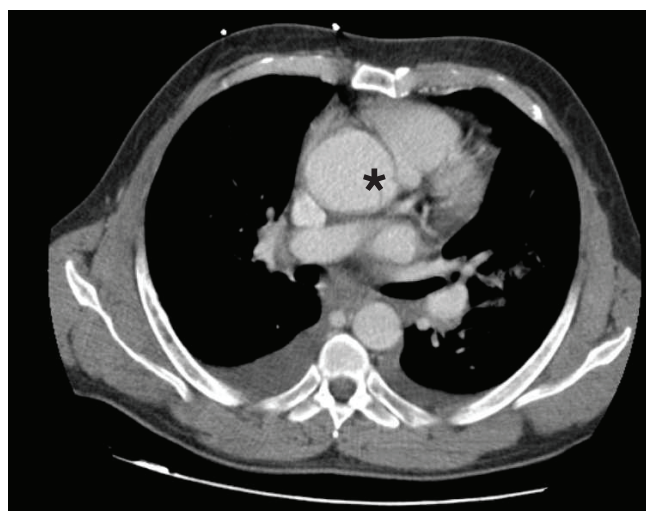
A CT angiography scan with contrast administration was not demonstrative of aortic dissection. The faint intra-aortic line seemed more like an artifact (asterisk).
